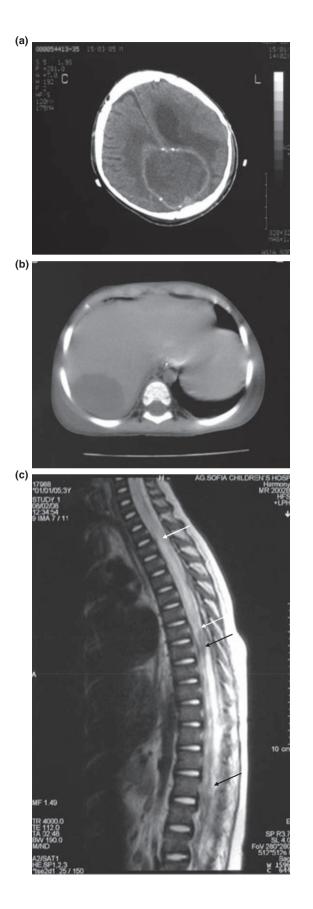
(a) Computed tomography (CT) scan showing a large, hypodense, interhemispheric mass lesion with ring contrast enhancement compressing both lateral ventricles with extensive surrounding oedema. (b) Abdominal CT scan showing two low density areas, one in the right liver lobe and the other in the border between the right and left lobes. (c) Spine magnetic resonance imaging T2-weighted image showing extensive intramedullary oedema of the thoracic spinal cord (white arrows) and epidural fluid entrapment at the thoracolumbar junction (black arrows).
